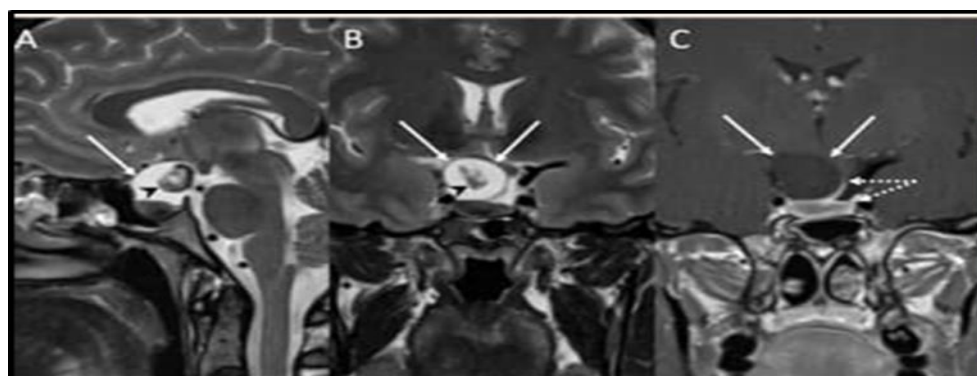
Rathke cleft cyst. Sagittal (A), coronal T2 (B) & contrast-enhanced T1-weighted (C)(11).
